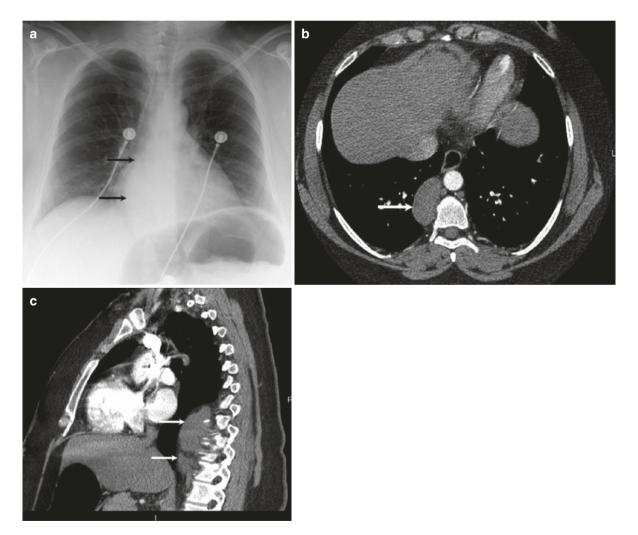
35-year-old woman with ganglioneuroma in the posterior mediastinum. (a) Frontal radiograph shows retrocardiac opacity displacing the right paraspinal line (arrows), while the azygoesophageal recess is preserved. (b) Axial CT image shows a
